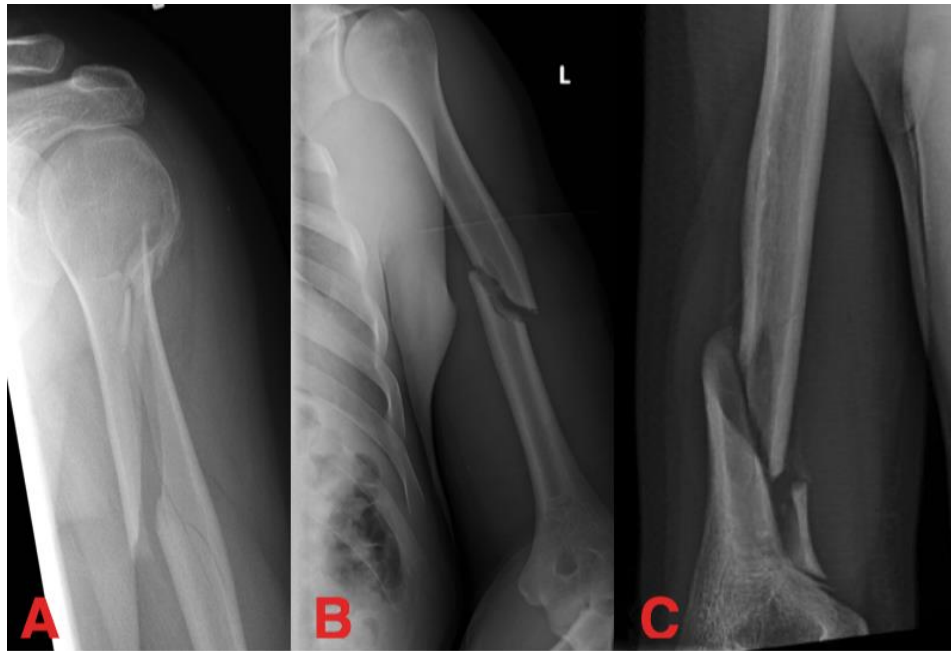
Plain film AP radiographs showing (A) proximal humeral shaft spiral fracture, (B) midshaft humeral fracture (C) distal humeral shaft spiral fracture (a Holstein-Lewis fracture) (4). Adapted from RSJThompson [CC BY-SA 3.0 (<https://creativecommons.org/licenses/by-sa/3.0/>)], James Heilman, MD [CC BY-SA 4.0 (<https://creativecommons.org/licenses/by-sa/4.0/>)], and Adam of spiralhumerusfracture.blogspot.com/ [Public domain].
